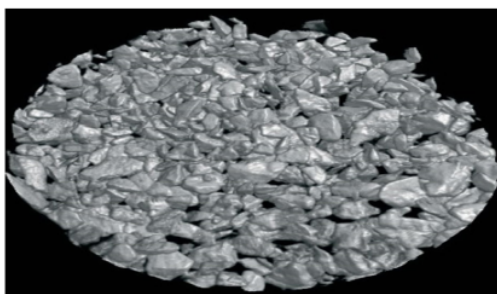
The shape of DDM scaffold particles in 3D images of μ -CT. (24 p.197)
